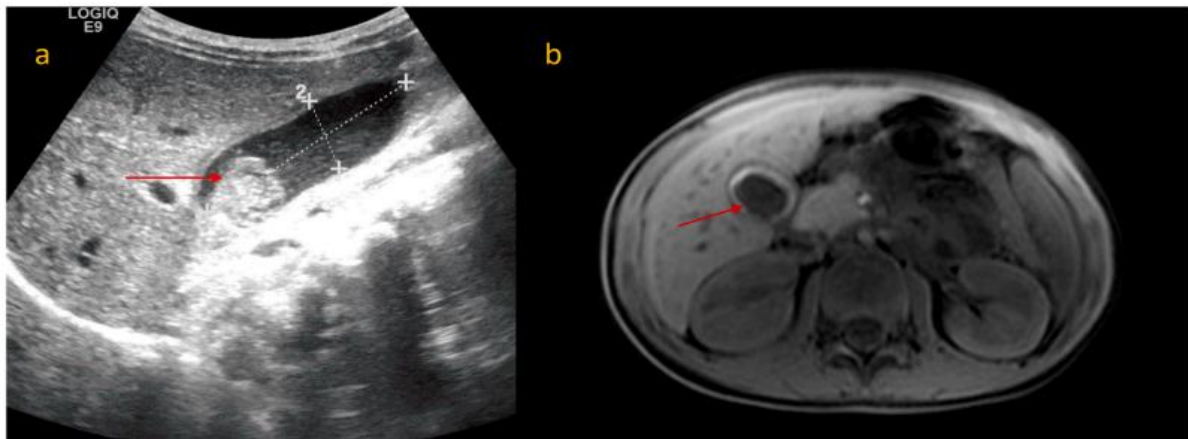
(a) Abdominal ultrasound measuring 2.7×1.8 cm mass in the gallbladder. (b) CT scan showing mass in the neck of the gallbladder
